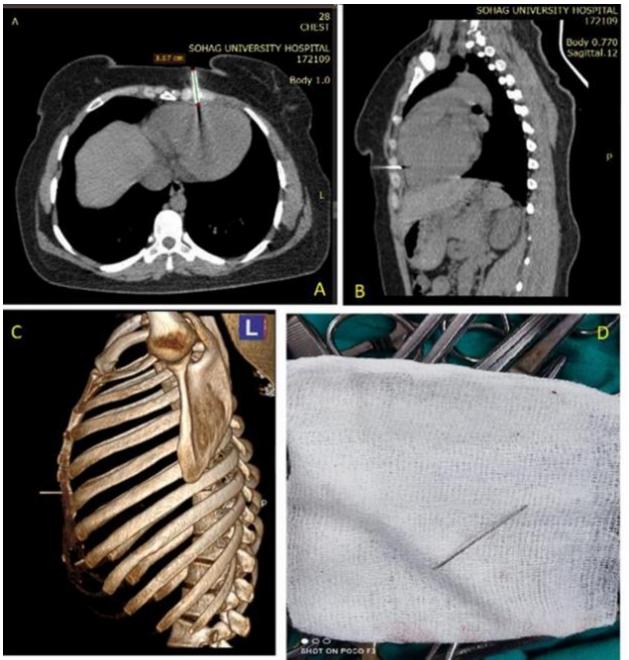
Female patient (nurse) 28 years old, non-enhanced CT chest A- Axial Scan, B- Sagittal reformate, C- 3D reformate, which is showing radiopaque needle (3.6 cm), which is totally penetrating chest wall Lt substernal, D- After surgical extraction the foreign body approved to be a broken syringe needle.
